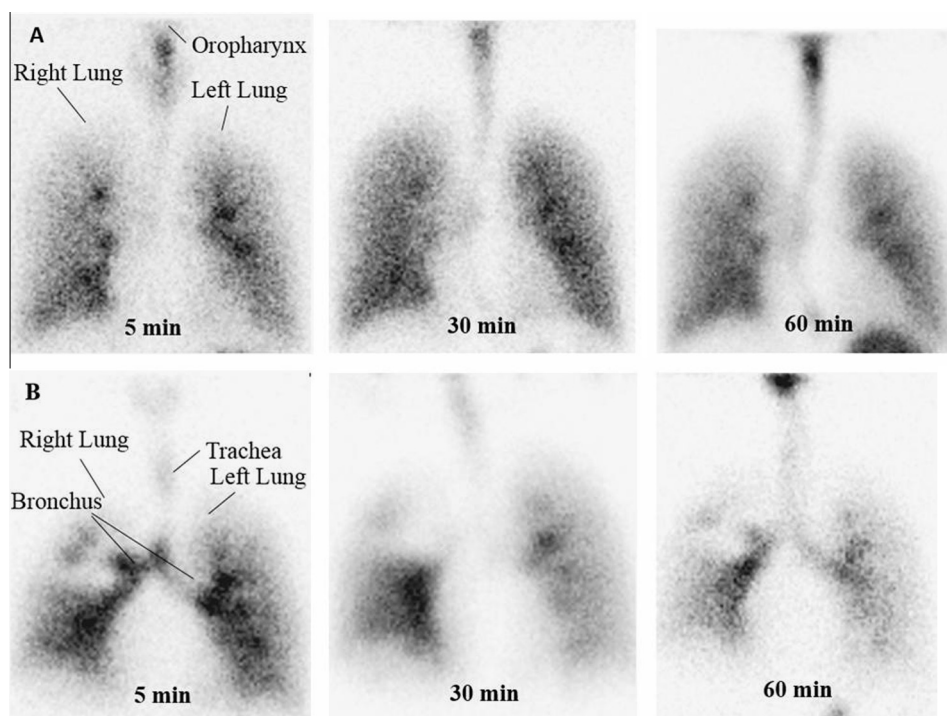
Gamma scintigraphy showing in vivo pulmonary deposition pattern of submicronic 1.25% arginine respiratory formulation in (A) healthy volunteer, (B) COPD patient, showing distribution of the drug at 5, 30 and 60 min after inhalation.
